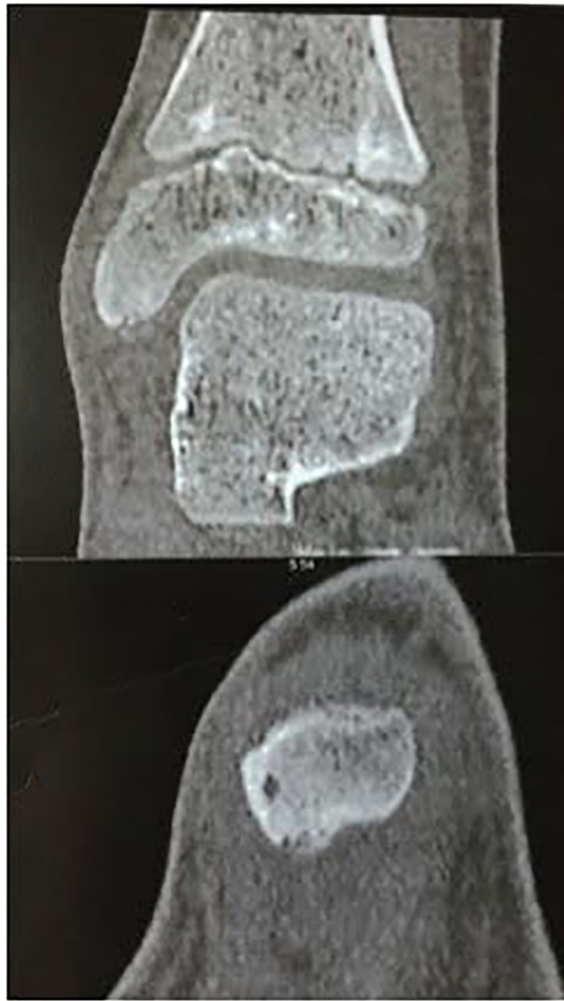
Coronal and sagittal CT scan show a fragmentation on the apex of the symptomatic left medial malleolus.
